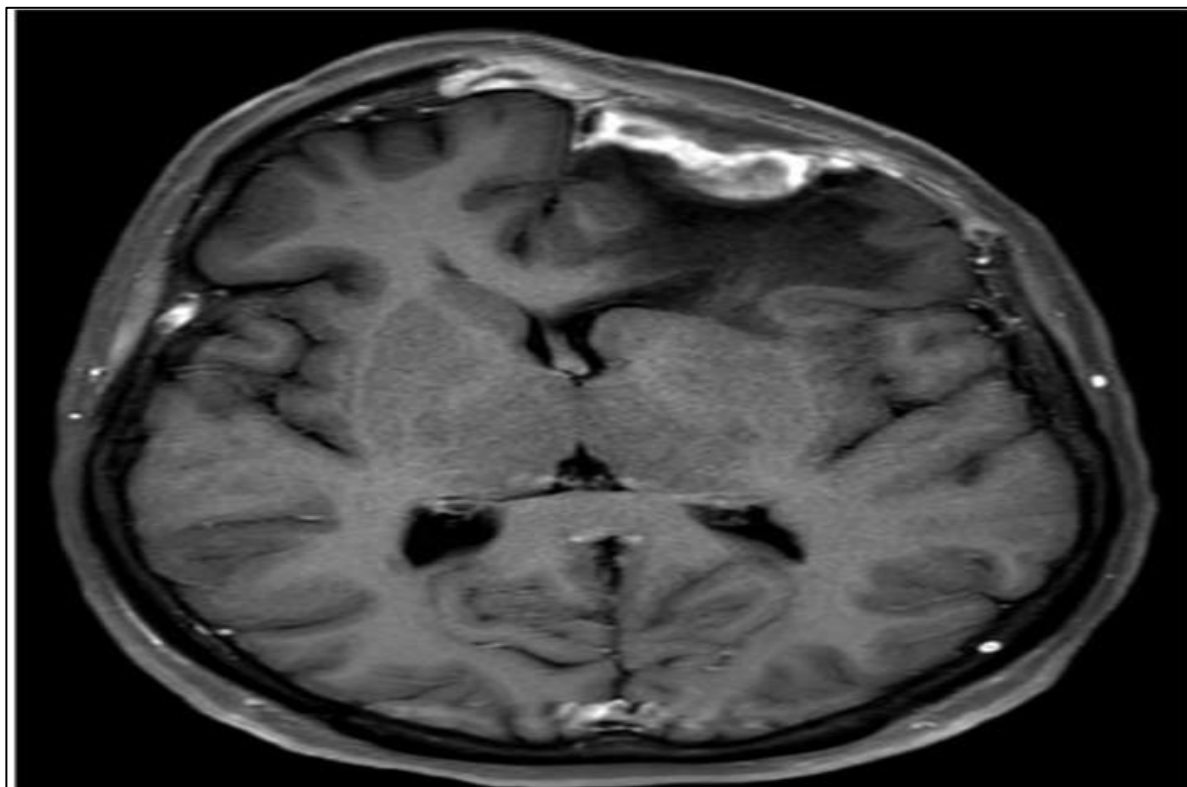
Axial Section of a Brain MRI after Injection of Gadolinium Showing a Residual Tumor in the Left Orbital Roof with Persistent Extradural Extension
